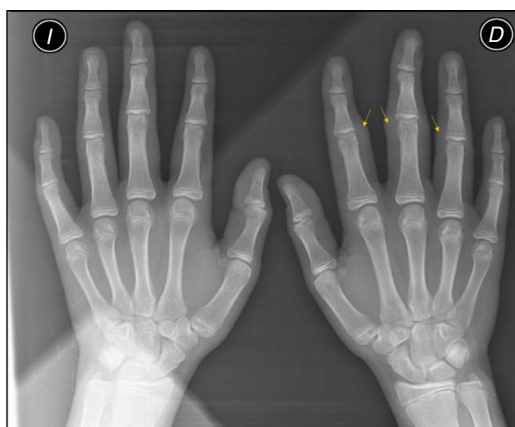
Radiographic image with increase in soft tissues on the second, third, and fourth IPJ of the right hand, with no signs of associated joint or bone involvement (arrows).
